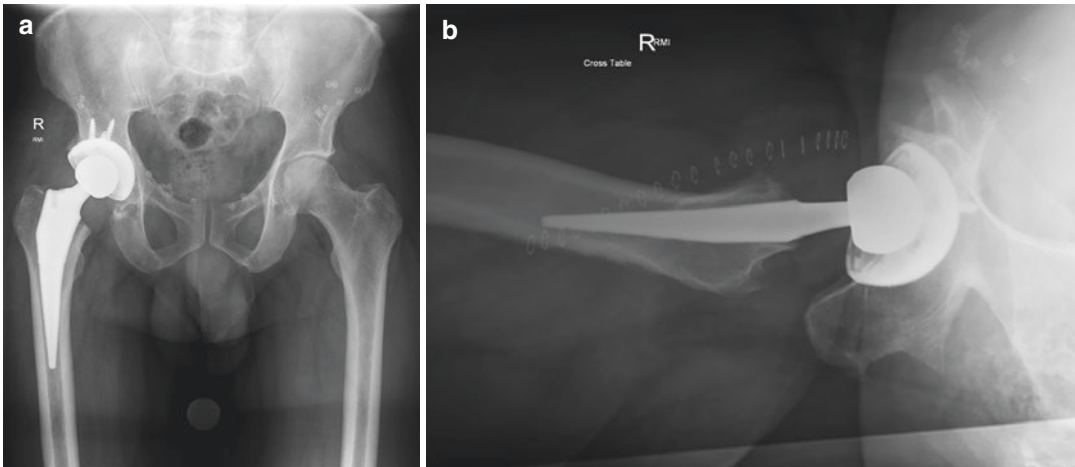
AP (a) pelvis and direct lateral (b) radiographs of a patient with a right total hip replacement. Note slight undersizing of the femoral stem in the coronal plane (a) with predominantly 3-point fixation of the stem noted on the lateral (b). This may be functional, but is not optimal
